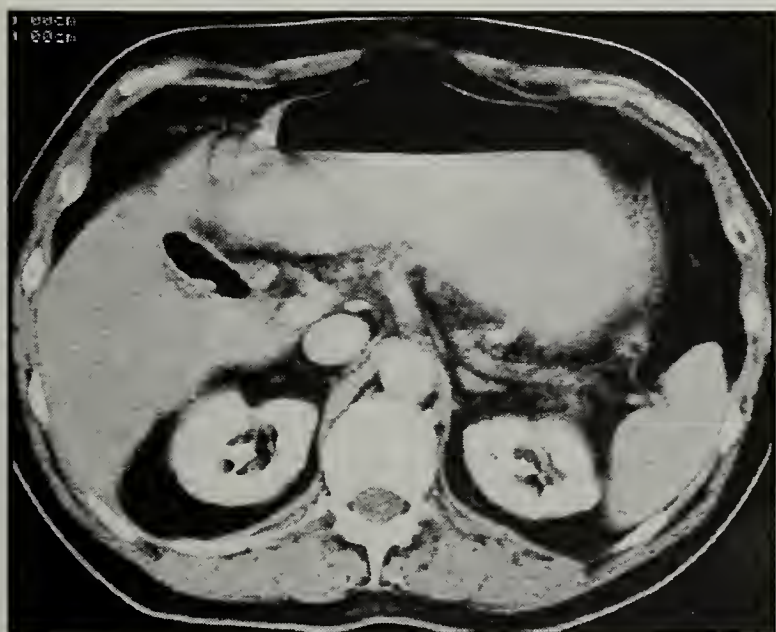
CT scans of upper and lower abdomen.
